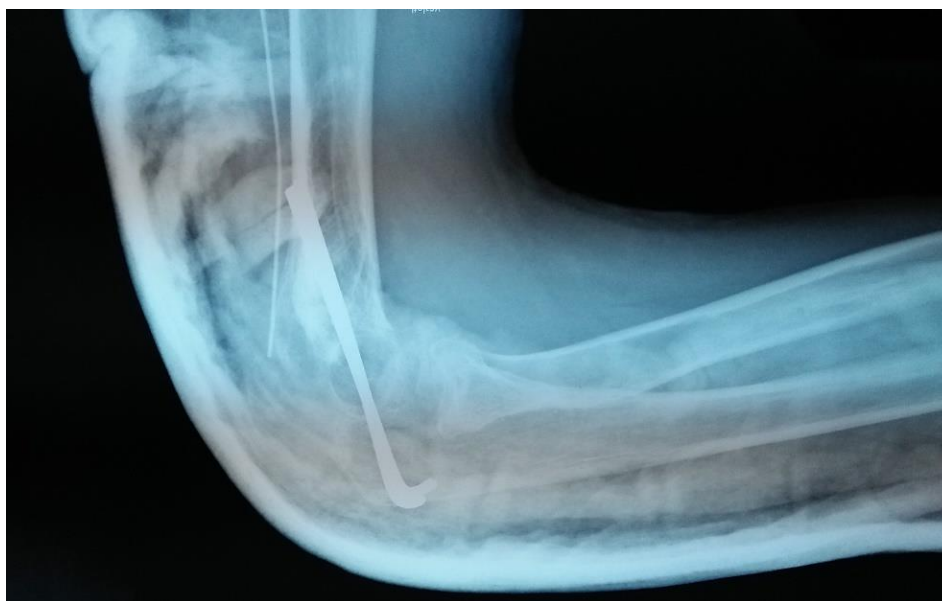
Postoperative control X-ray
